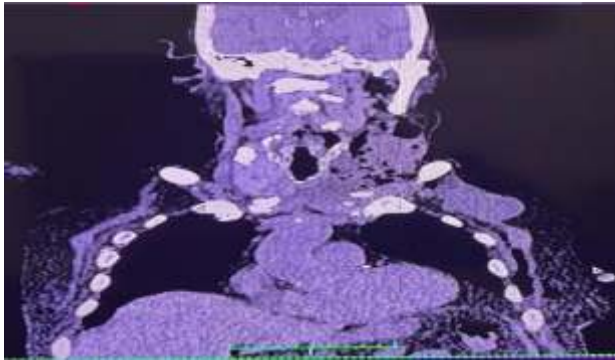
CT Neck and chest
